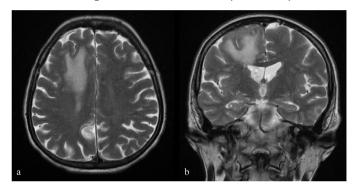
Magnetic resonance imaging of the brain. T2-weighted axial (a) and coronal (b) images showed a metastatic lesion in right frontal convexity along the cortical-leptomeningeal face, accompanied by dural thickening, and white matter edema in the adjacent frontal lobe parenchyma. Two points of cortical-subcortical diffusion restriction suspected for metastasis were observed in the right posterior parietal lobe
